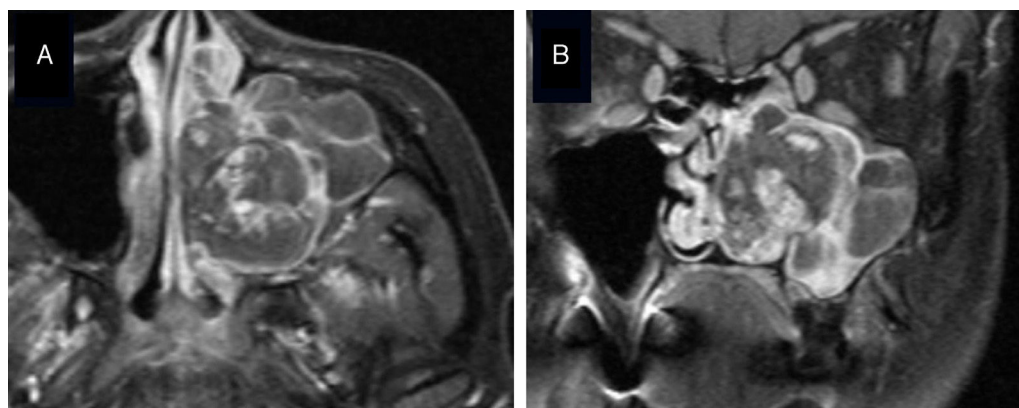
Gadolinium-enhanced MRI of Case 2. Axial (A) and coronal (B) images. A heterogeneously enhanced vascular tumor was suspected.
